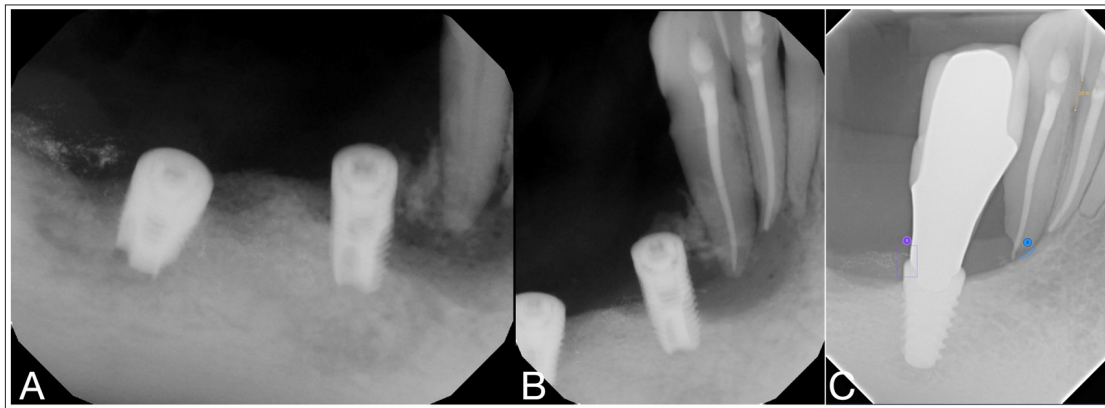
A) and B) represent pre-operative radiographs of MRONJ lesions affecting teeth #26, #27 and Implants #28 and #30. C) 3-year post-operative radiograph after a new implant at #28 was placed
